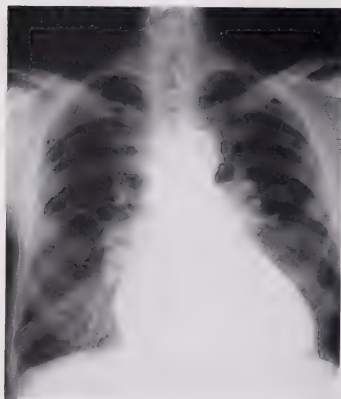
Chest x-ray with generalized enlargement of the heart and increased hilar markings.
